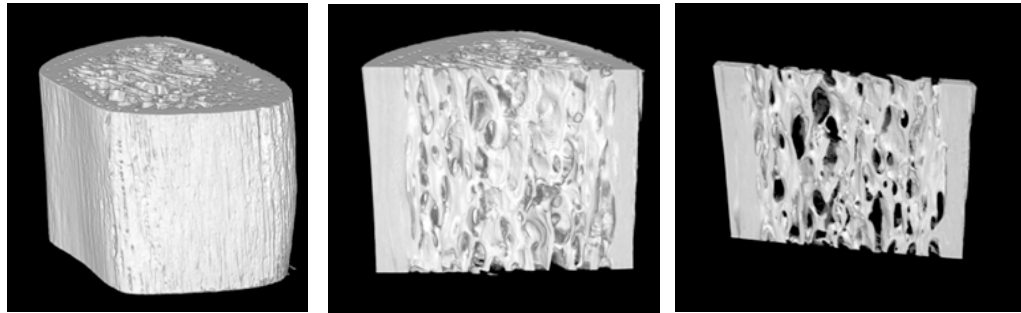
3D rendering from X-ray Tomography scan of mature rib section taken before mechanical testing.
